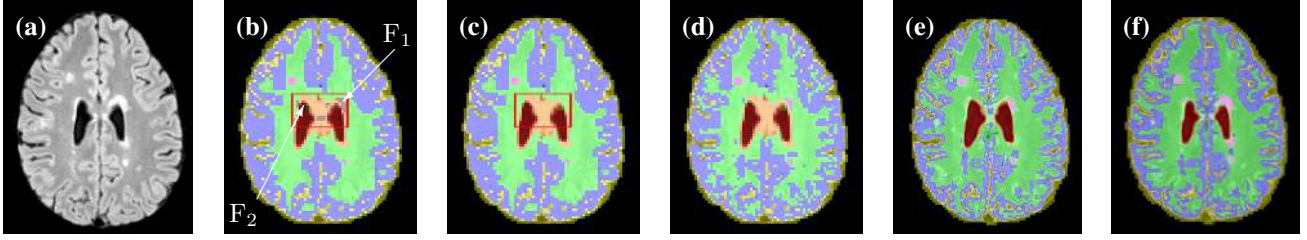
Method overview. Given the input images including the FLAIR image (a), minimizing $E_0(f)$ produces the initial labeling (b), which contains the false labels F_1 (grey) and F_2 (dark green). After removing the false labels (c), the method improves the computed minima in a coarse-to-fine approach (d-f).
